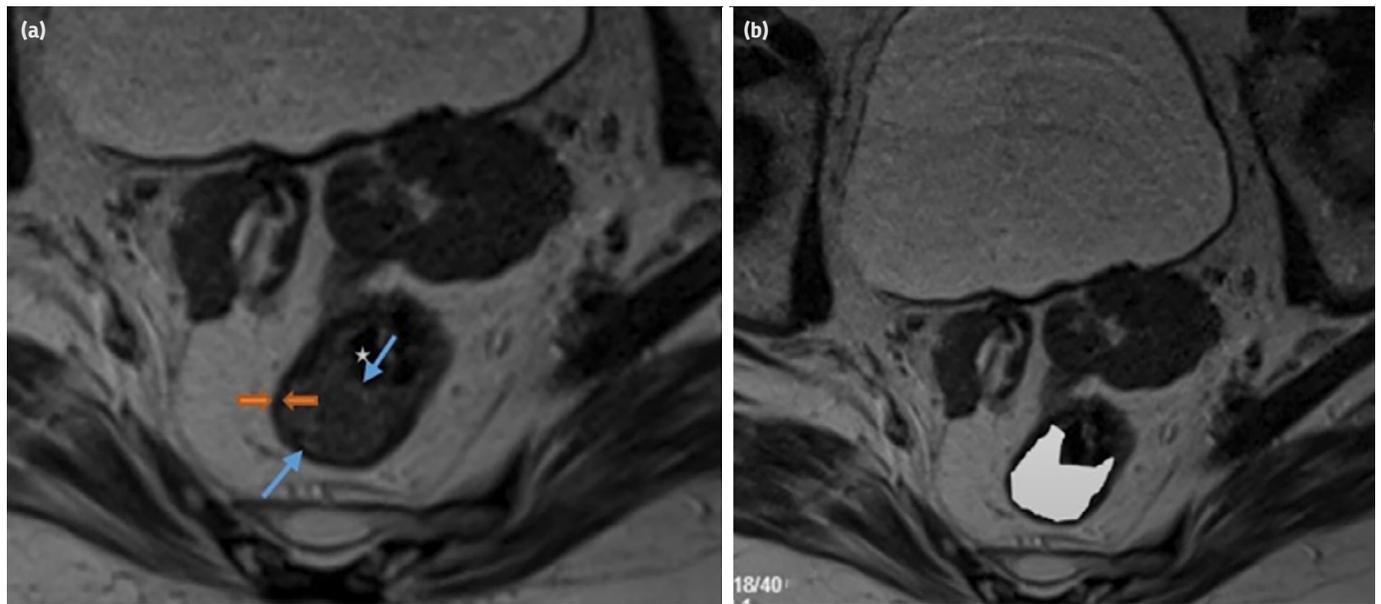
T2 rectal tumor: Rectal cancer has been found in a 76-year-old patient. Eight weeks following neoadjuvant chemoradiotherapy treatment, a high-resolution T2-weighted axial (a, b) MRI scan appears to accurately predict the T stage as T2 (pathological stage T2). An intact muscularis propria is seen (orange arrows). When compared to the muscularis propria, the tumor tissue was seen at an intermediate intensity (hyperintense) and had asymmetric semicircular wall involvement (between blue arrows). (b) The tumor tissue's boundaries are drawn. An asterisk marks the colon's open lumen
